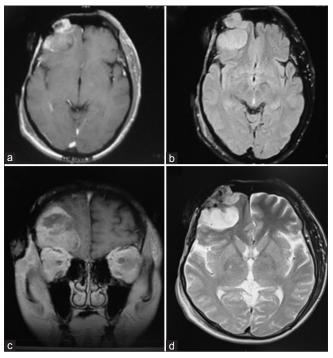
The MRI scan showing (a) lobulated mass at frontal region which (b) enhanced homogenously after contrast administration. (c) The mass extends to the frontal base viewed by coronal plane and (d) shows various intensity on T2 imaging
